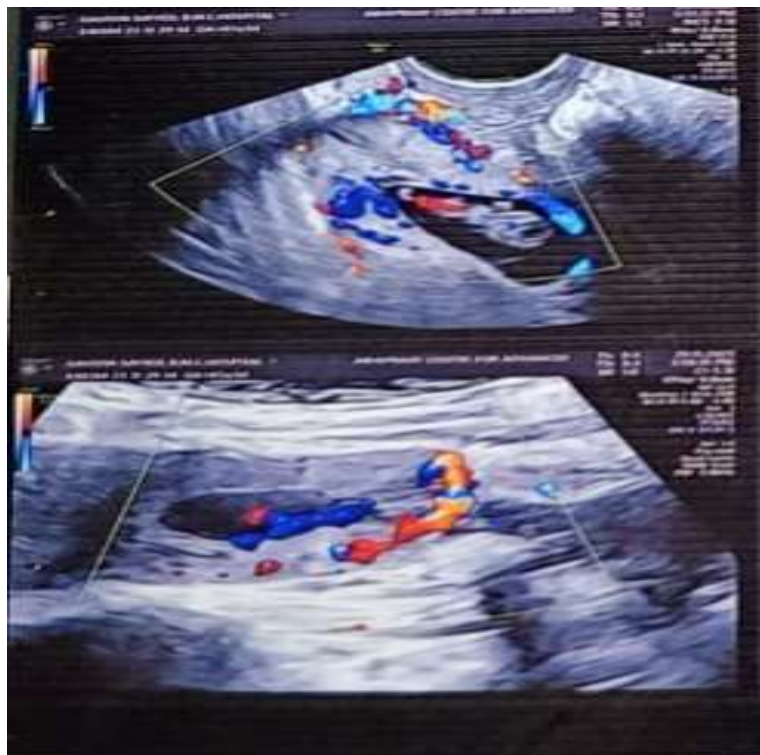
Transvaginal ultrasound with colour doppler showing cesarean scar ectopic pregnancy.
